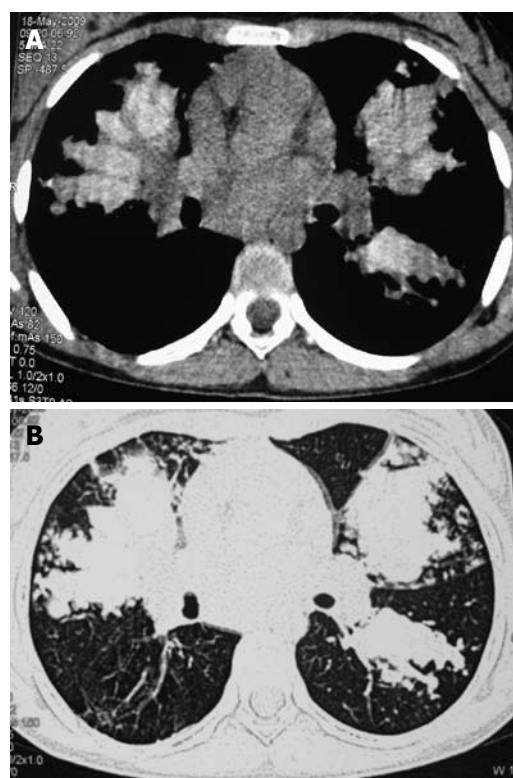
High-resolution computed tomography of the chest showing high-attenuation mucus in a patient with allergic bronchopulmonary aspergillosis (mediastinal window, right panel). The corresponding lung window is also shown on the left panel.
